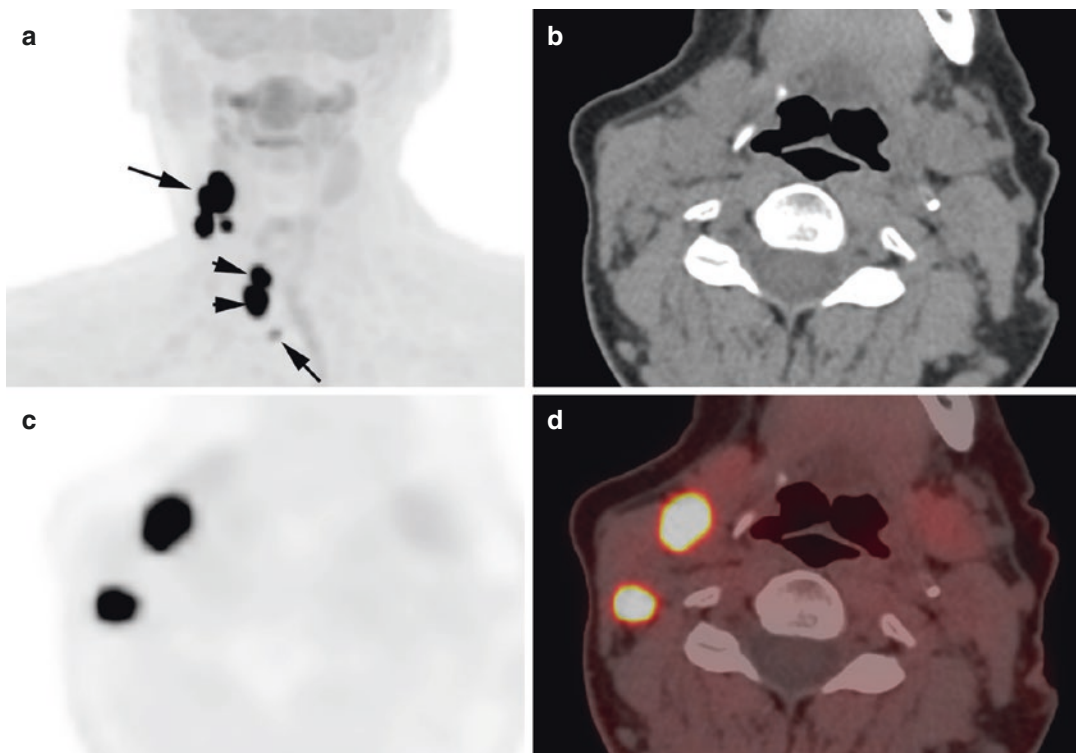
^{18}F -FDOPA PET at initial diagnosis of MTC in a sporadic case. ^{18}F -FDOPA PET/CT shows 2 right MTC (a, arrowheads) and LN in the central and right lateral neck compartments (b–d, arrows)
